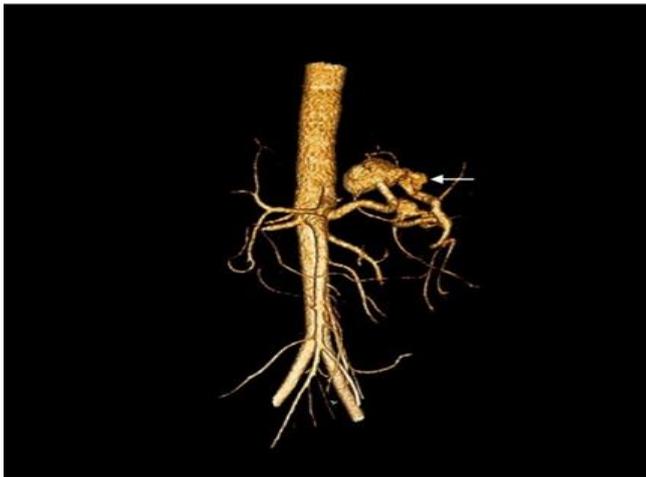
volume-rendered CT Arteriogram images of two patients with extrahepatic portal vein occlusion show tortuous Splenic artery with aneurysmal dilatations (\leftrightarrow).
